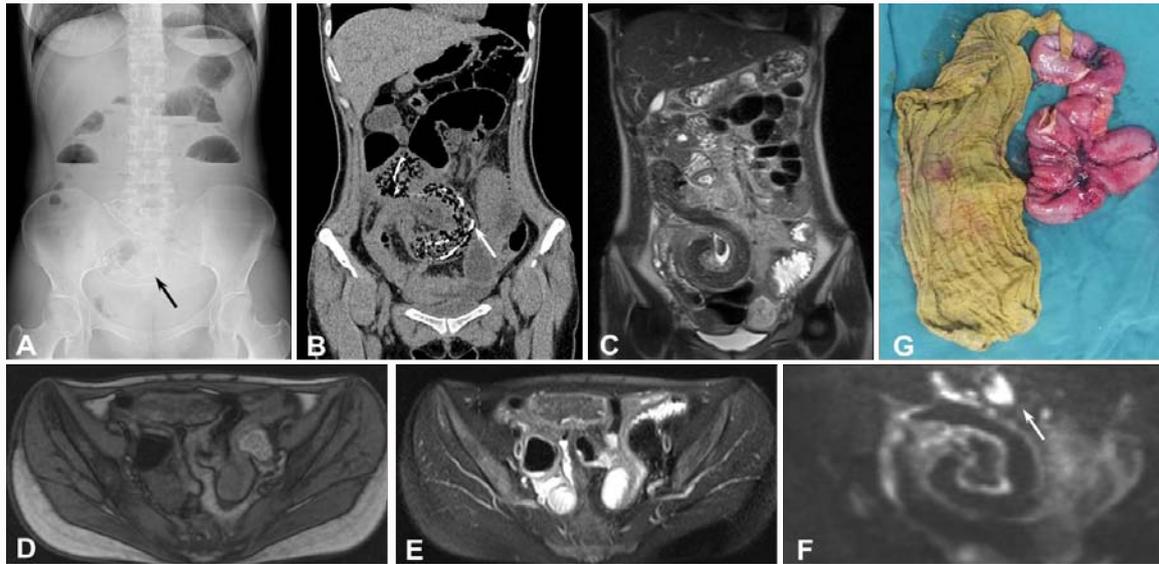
A 29-year-old woman who presented with intestinal obstruction 4 months after caesarean section. A: KUB showed a high-density image in the hypogastrium (black arrow). B: Unenhanced CT scan shows honeycombed gauze foreign body in small intestine with visible metal marks (white arrow). C-F: MRI shows foreign body in small intestine, the intestinal wall is swollen and thickened, and lymph node enlargement around the intestine was clearly shown (white arrow).
